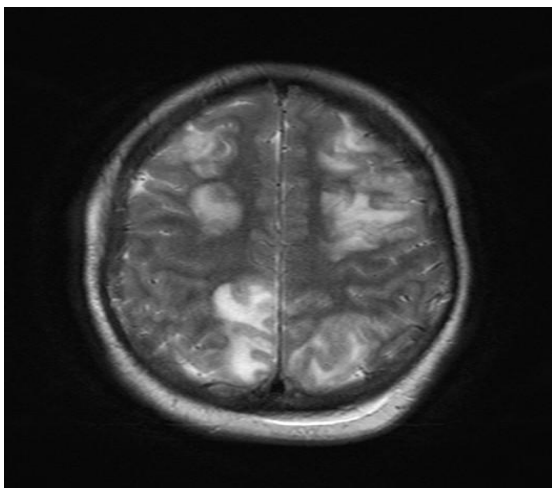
3 Axial (FLAIR) image showing bilateral hyper intensities in the occipital lobes.
